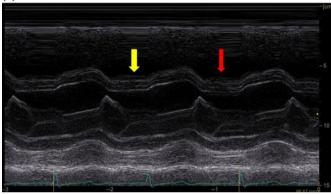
(a) Septal Motion in Right Ventricle Pressure Overload with Septal Flattening during Systole (Yellow Arrows) Worsened by Inspiration (Red Arrow); Inset B-mode Parasternal Long Axis Image at the Mid-papillary Level; (b) Volume Overload with Septal Flattening During Diastole (Yellow Arrows) Worsened by Inspiration (Red Arrow).
